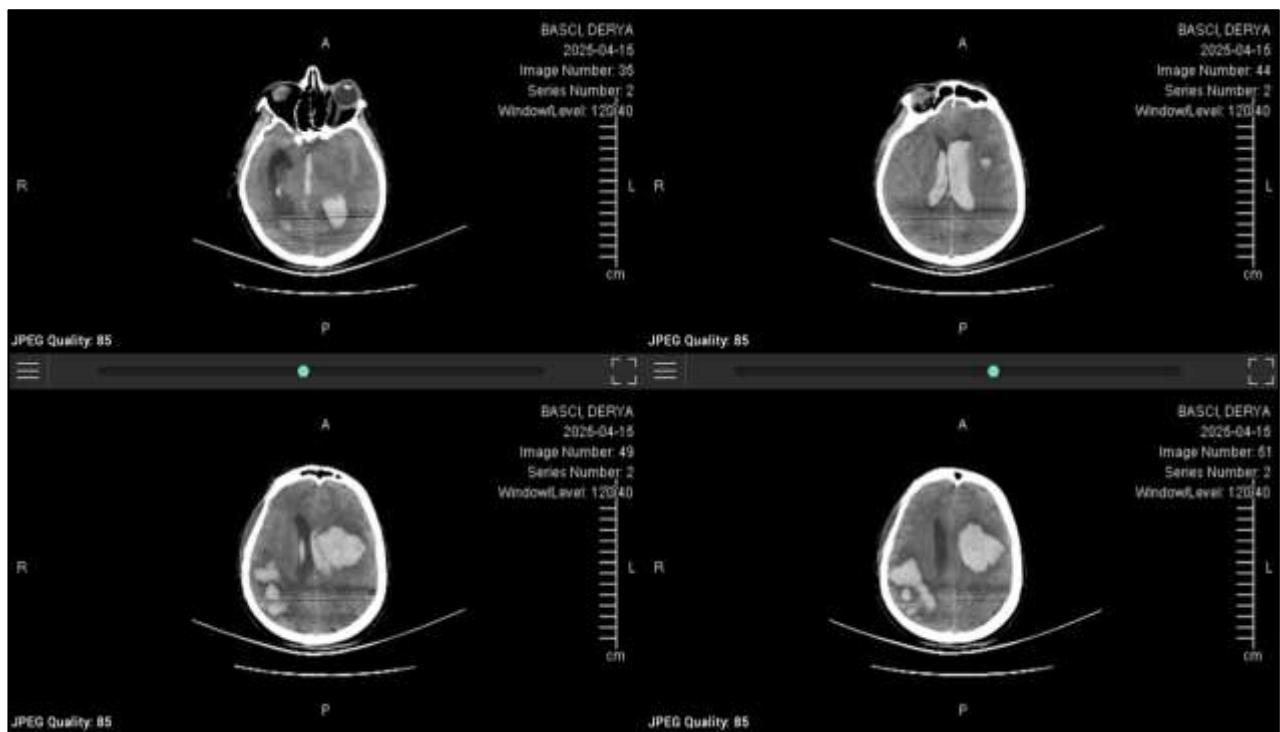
Non-contrast cranial CT demonstrating bilateral parenchymal hematomas, the largest measuring 45 mm in the left hemisphere.
